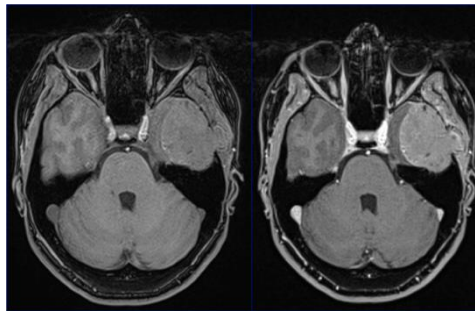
Brain MRI: T1, T2, and FLAIR sequence showing the expansive lesion.
